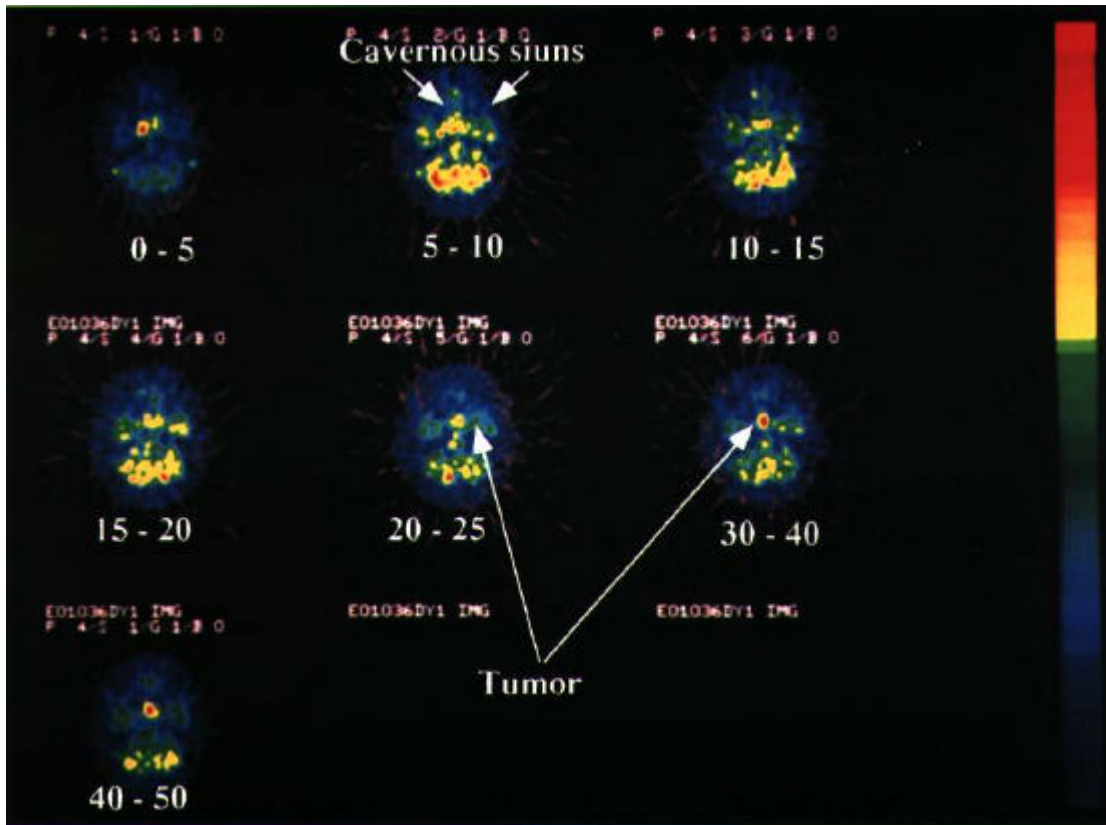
¹⁸F-FDG PET dynamic images of case 1. (arrow: pituitary adenoma, arrow heads: cavernous sinus)
